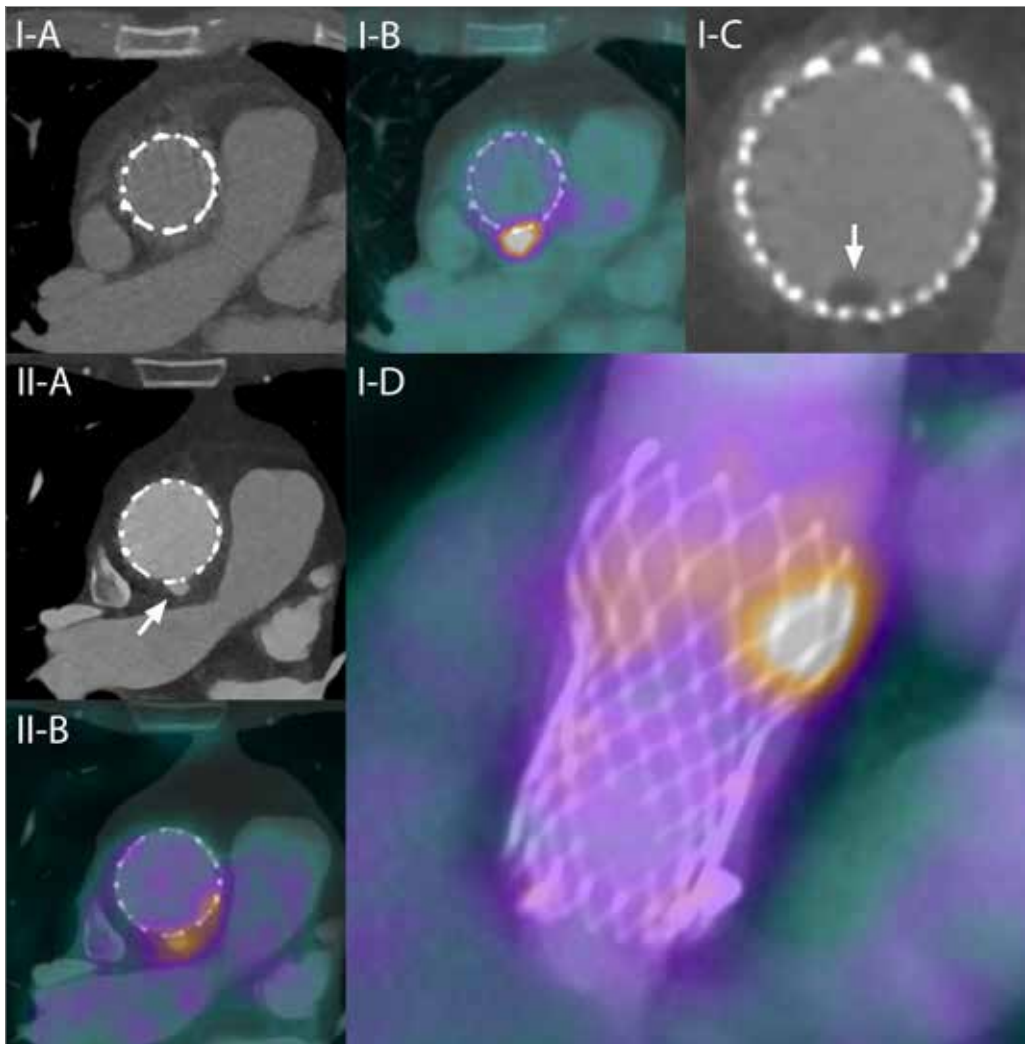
(I-A) Double-oblique CTA image of the distal TAVI stent showing some slight induration around the prosthesis, particularly on the dorsal side. (I-B) Fused PET/CTA showing intense focal FDG uptake on the dorsal side of the distal TAVI stent. (I-C) Enlarged slightly more proximal slice of the distal TAVI stent showing a tiny area without contrast, indicating a possible vegetation. (I-D) Fused PET/CTA 3D maximum-intensity projection showing the entire TAVI prosthesis and the localization of the FDG uptake. (II-A) Follow-up CTA after 6 weeks of antibiotic treatment, showing a small mycotic aneurysm or ulcer at the site of increased FDG uptake. (II-B) Follow-up fused PET/CT showing FDG uptake that has diminished but not completely disappeared.
